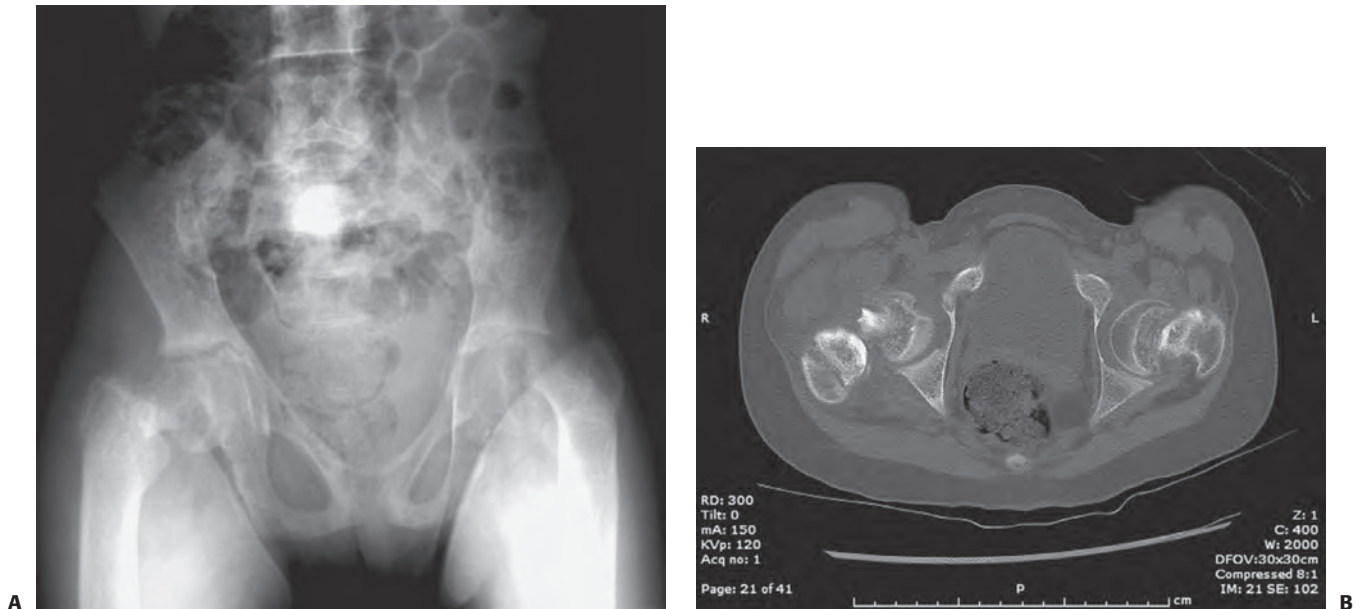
This 13-year-old boy with renal osteodystrophy presented with bilateral hip and thigh pain. A: Anteroposterior pelvic radiograph shows widening of the proximal femoral physes with sclerosing. Slipped capital femoral epiphyses were diagnosed. B: This anteroposterior pelvic radiograph taken 9 months after surgery shows narrowing of the physis and no evidence of further displacement of the capital femoral epiphyses. (Figures reproduced with permission from The Children's Orthopaedic Center, Los Angeles, CA.)
